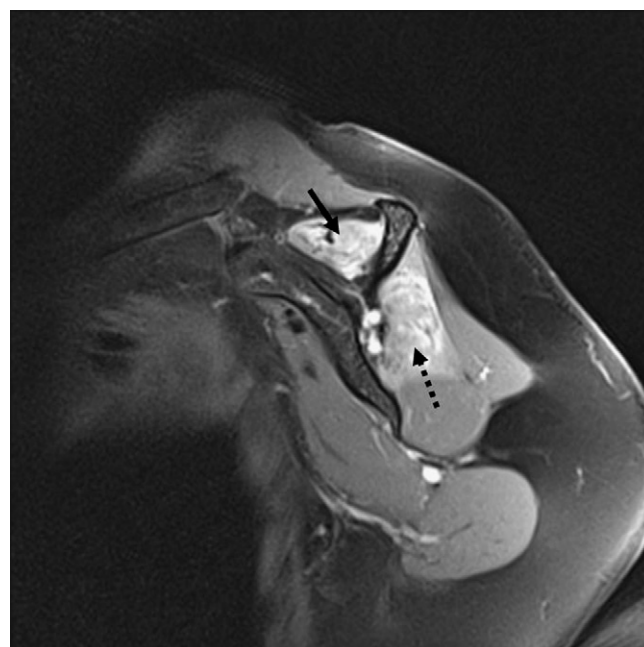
Sagittal proton density with fat suppression MRI of the left shoulder demonstrating hyperintense signals in the supraspinatus (black arrow) and infraspinatus (dotted arrow) consistent with acute denervation.
